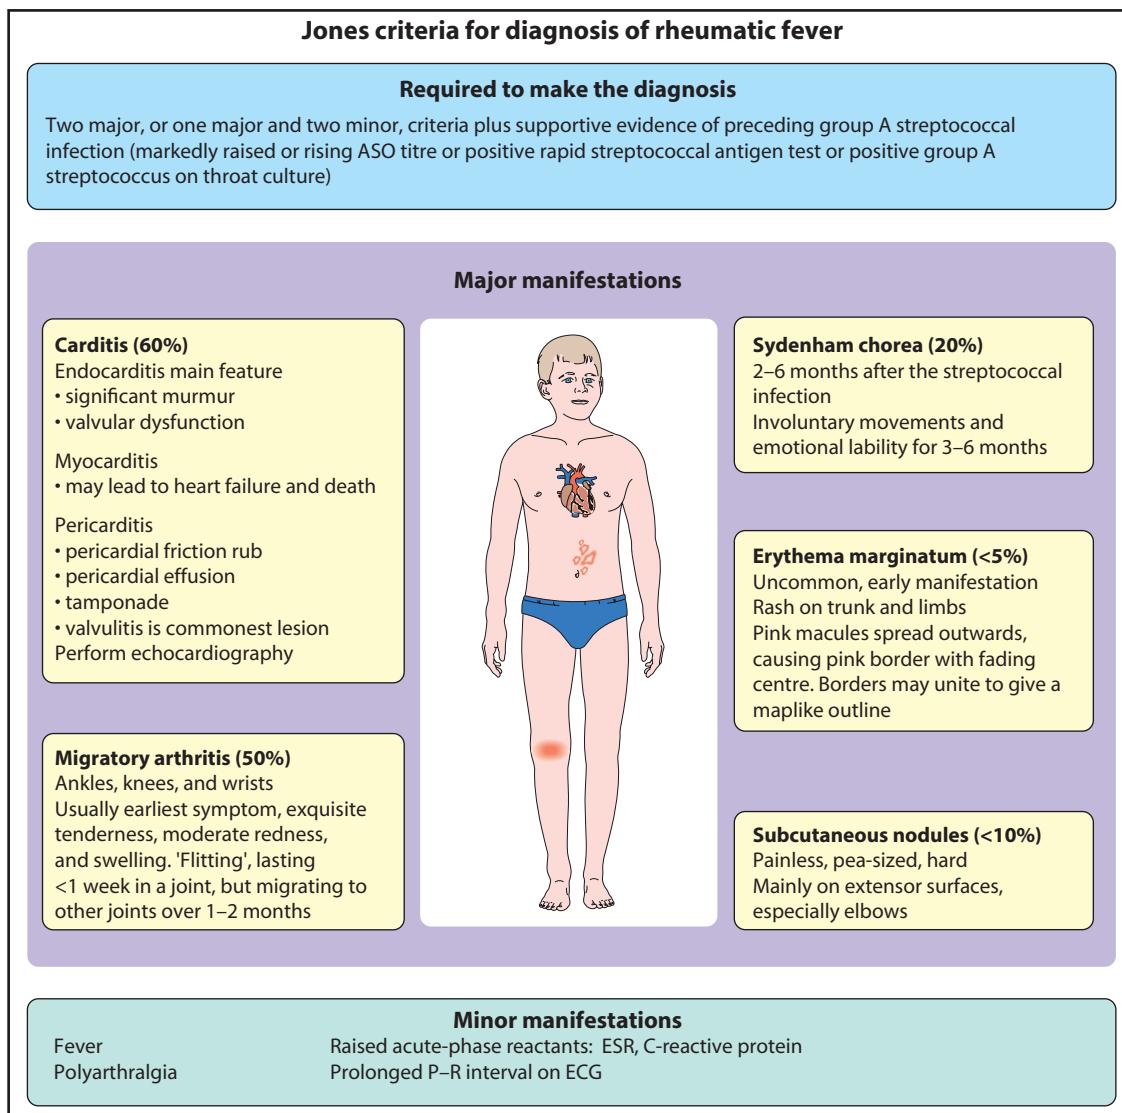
Jones criteria for diagnosis of rheumatic fever. If acute rheumatic fever is suspected, carditis should be diagnosed by echocardiography, if possible. In moderate to high-risk populations, monoarthritis or polyarthralgia may be considered a major manifestation of arthritis and monoarthralgia a minor manifestation instead of polyarthralgia.
